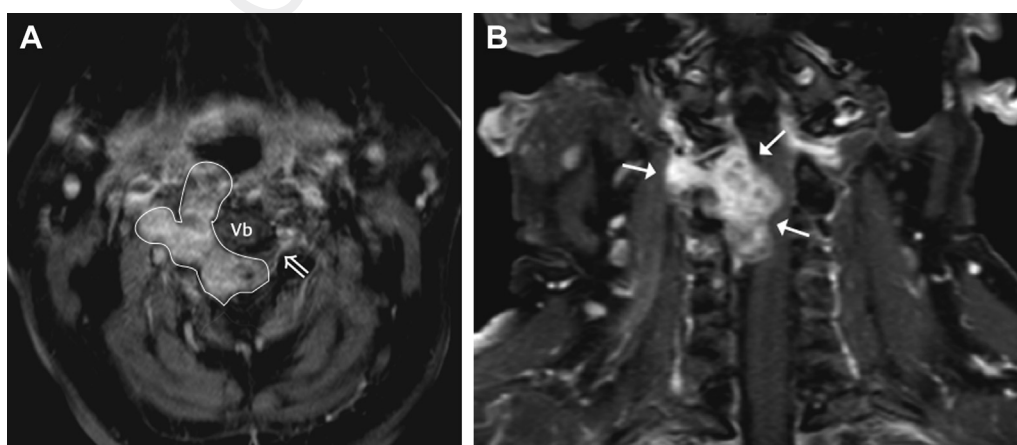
Cervical schwannoma. Axial (A) and coronal (B) fat-suppressed postcontrast T1-weighted magnetic resonance images demonstrate an avidly enhancing mass expanding the right C2-C3 neural foramen and causing lateral displacement and severe compression of the spinal cord from the C2 through C4 level (the mass is outlined in [A] and denoted by closed arrows in [B]). Vb, vertebral body; the open arrow in (A) points to the normal left neural foramen.
